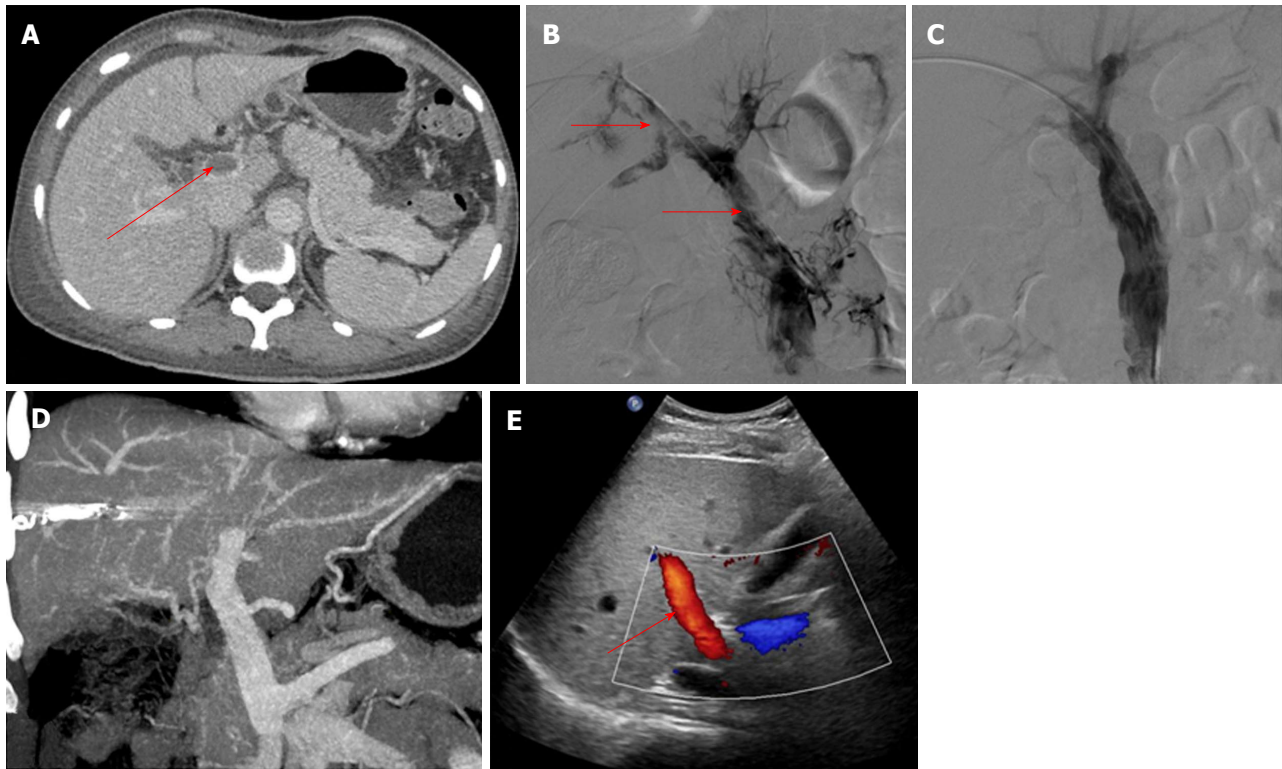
A 57-year-old woman had acute abdominal pain for 16 d. A and B: Contrast-enhanced computed tomography (CT) and portography via the percutaneous transhepatic route showed thrombus formation in the portal vein and superior mesenteric vein (arrow); C: Portography after agitation thrombolysis and catheter-directed thrombolysis showed that the filling defect in the portal vein had decreased; D: Contrast-enhanced CT after treatment showed that the thrombus had disappeared completely; E: At 12 mo after treatment, color Doppler ultrasound showed smooth blood flow in the portal vein (arrow).
